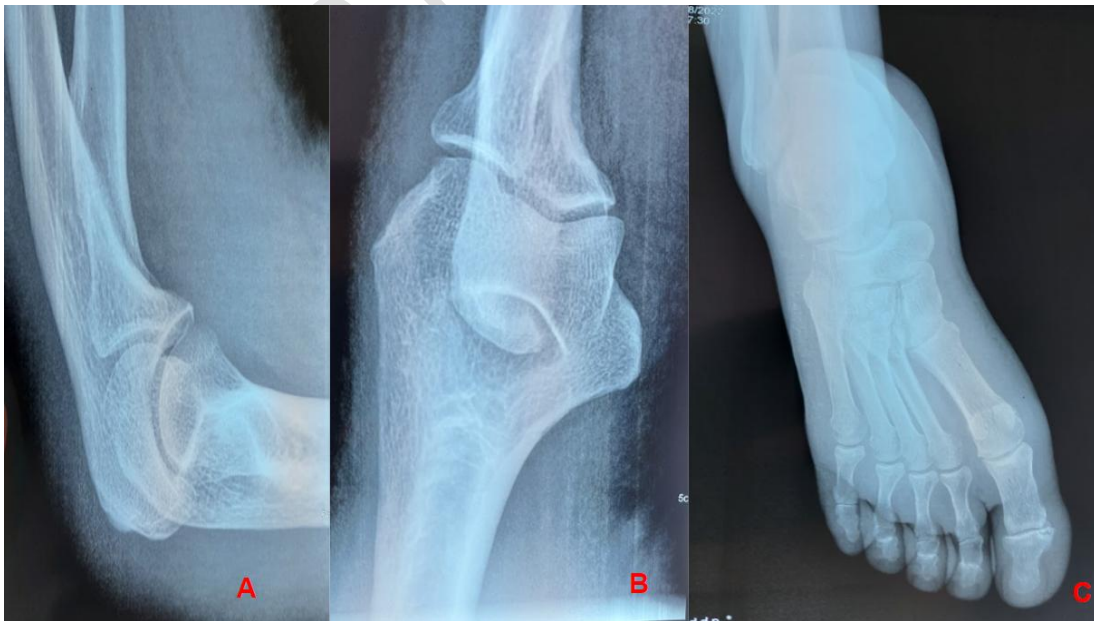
X-rays of the joints (A: elbow, B: knee, C: ankle)
